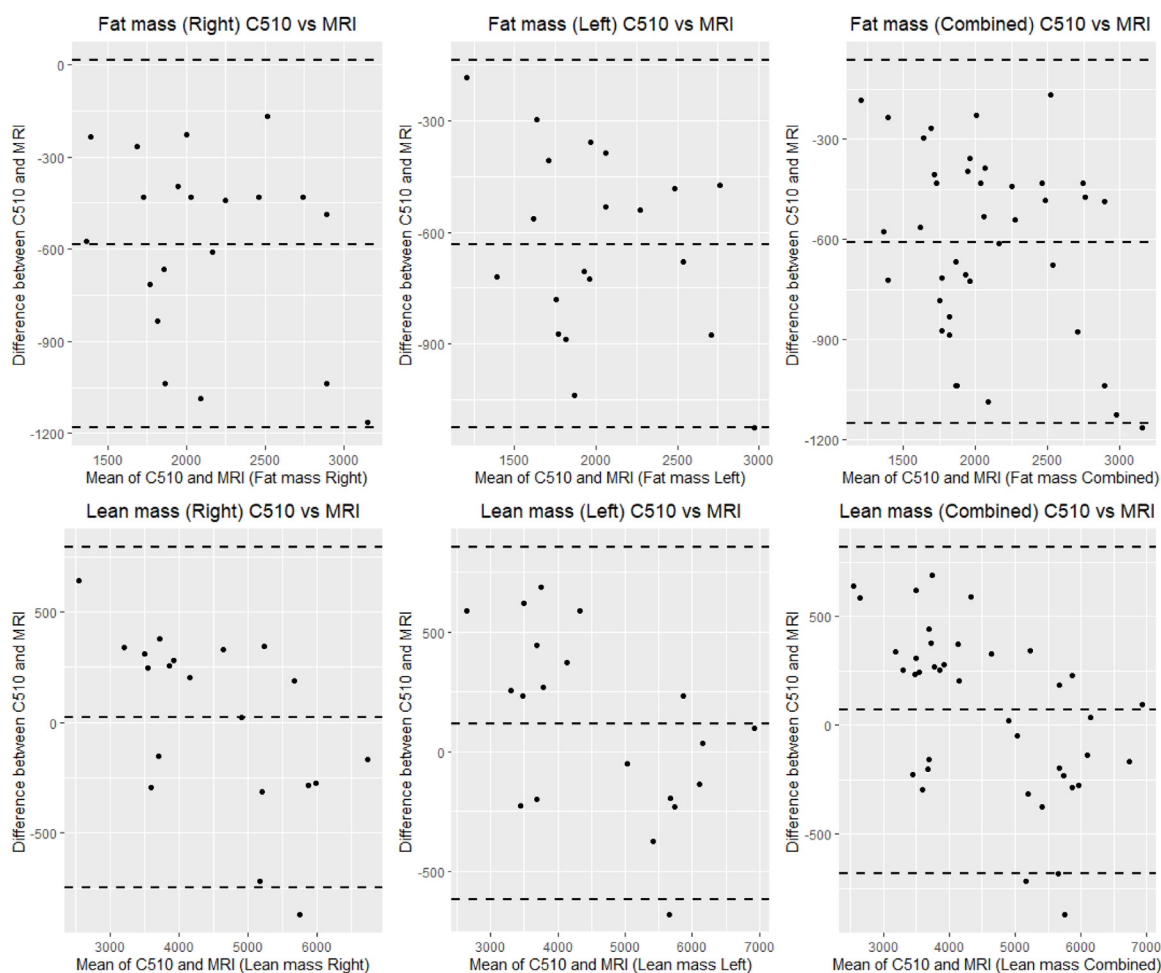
Bland-Altman plots for agreement between C510 and MRI measurements.
